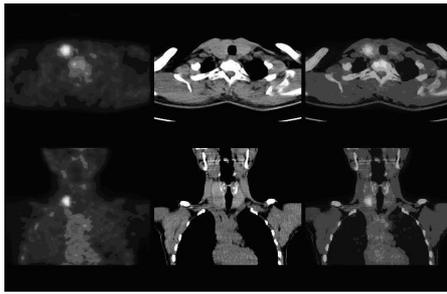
Benign focal incidental thyroid lesion detected by FDG PET imaging in a patient with Non-Hodgkin's lymphoma.
